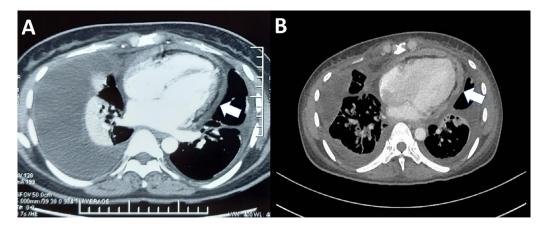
(A) Axial CT on May 13, 2020, revealed pericardial thickening. (B) Axial CT on November 24, 2020, revealed (B) irregular pericardial thickening with some calcifications and bilobular interlobular septal thickening suggesting of metastasis. Note that pericardial thickening in the first imaging was not as clear as second imaging maybe (due to the masking effusion).
